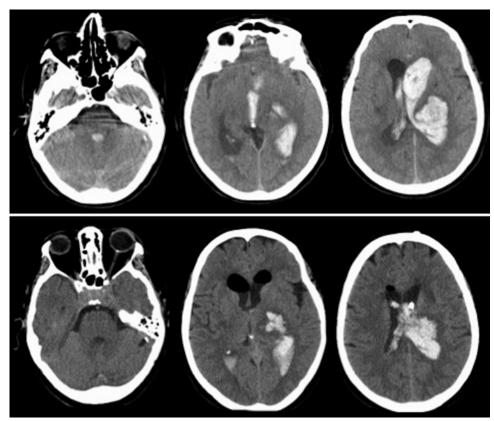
Preoperative (upper) and postoperative (lower) CT scans of a spontaneous thalamic hemorrhage with tetraventricular clots.
